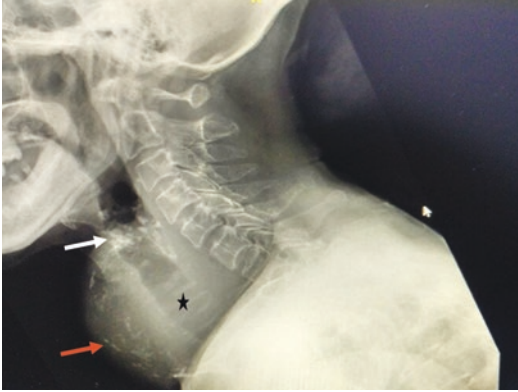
Head and neck imaging such as a neck X-ray complementing the clinical examination findings. This is necessary for a complete assessment of the head and neck disease. This lateral neck X-ray shows a huge thyroid mass (red arrow) with evident calcification (white arrow) and the shadow of trachea (star)
